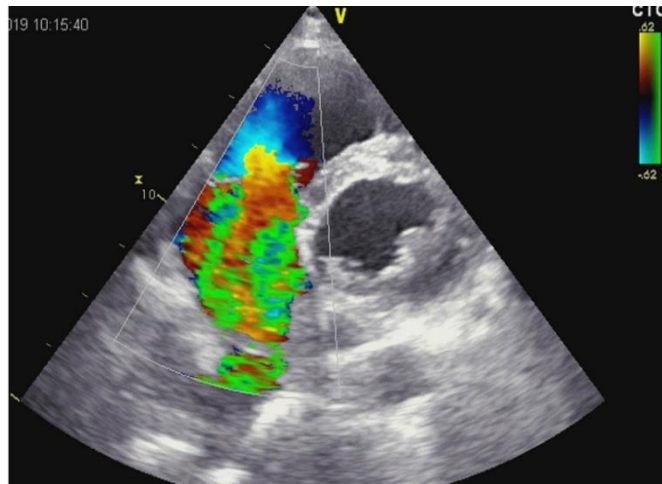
Transthoracic color doppler reveals massive tricuspid regurgitation
